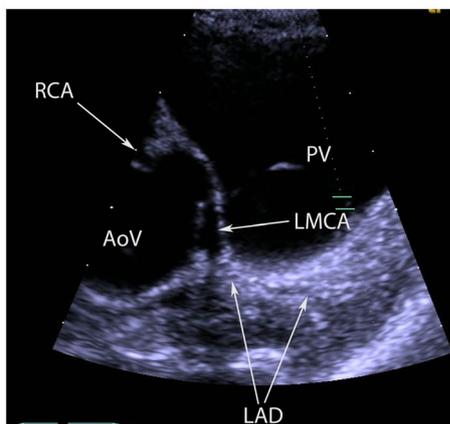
Echocardiogram demonstrating typical anatomy of an anomalous LMCA with an intraconal course
